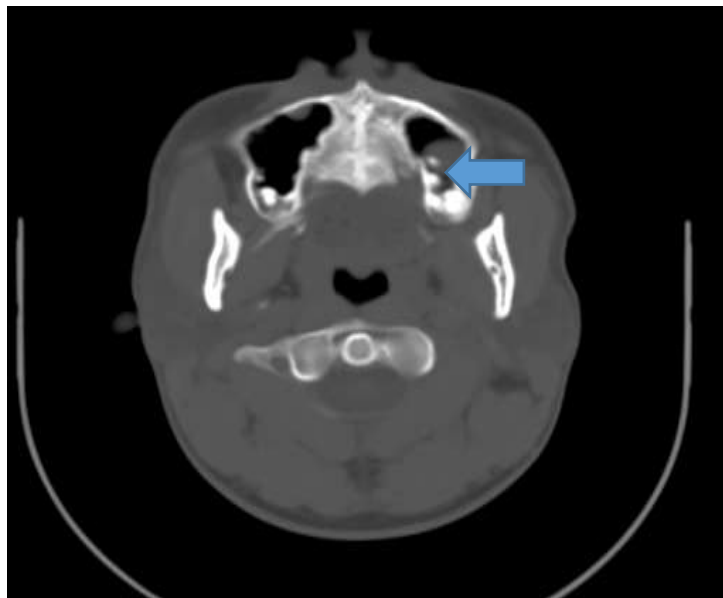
Axial head CT bone window of a 25 year old male who presented with chronic headache and nasal blockage. CT showed a well-defined soft tissue density mass in the floor of left maxillary sinus that was consistent with a polyp
